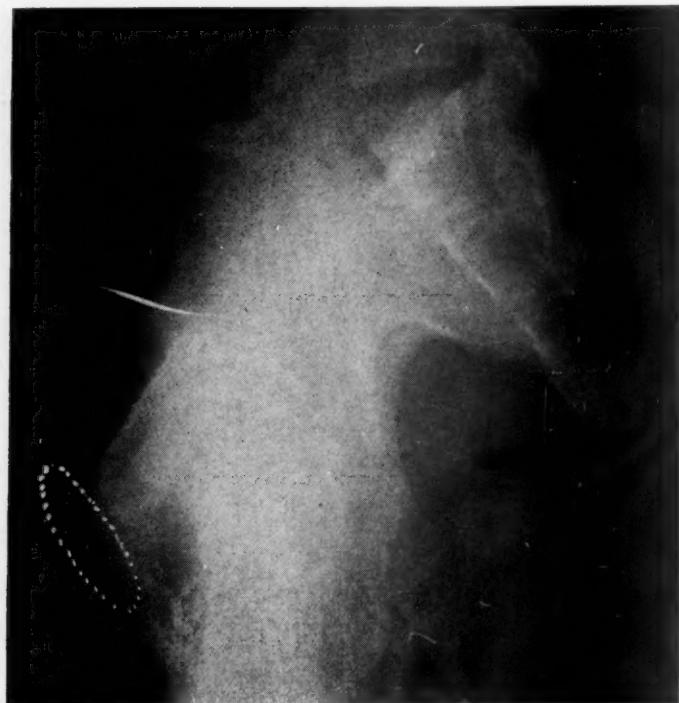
Small mesatipelvic type pelvis, anteroposterior 10.4, transverse 11.4. The promontory rests 2.0 cm. above the posterior end point of the true conjugate. Roentgenogram shows a breech presentation in a primigravida. The diagonal conjugate is 13.0 cm. from which the true conjugate estimation of 11.5 gives an error of 1.1 cm.
